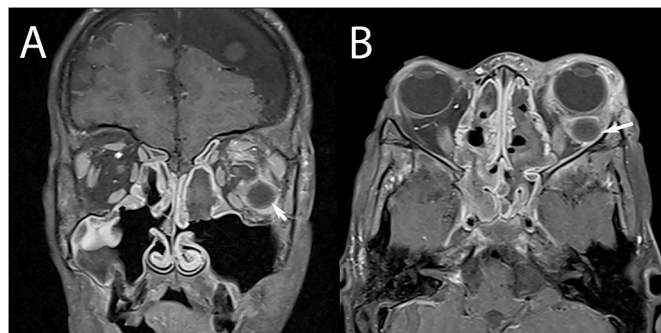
3A: Coronal section of T1-weighted contrast-enhanced MR orbital study demonstrating recurrence of inferior orbital abscess five days after initial surgical intervention (day 13).
